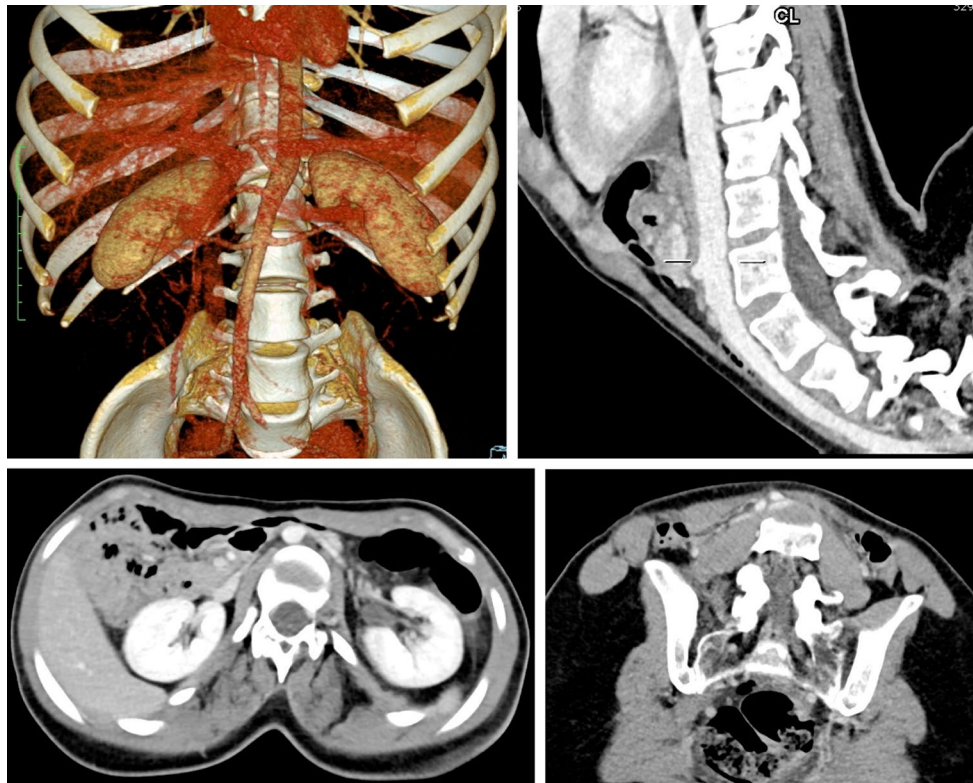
Images from an Angio-CT that was performed to help decide on the best surgical strategy. Top left: 3D reconstruction. Top right: sagittal plane view, showing aorta and a gas-filled abdominal organ (stomach or duodenum) stretched out over the apex of the deformity
